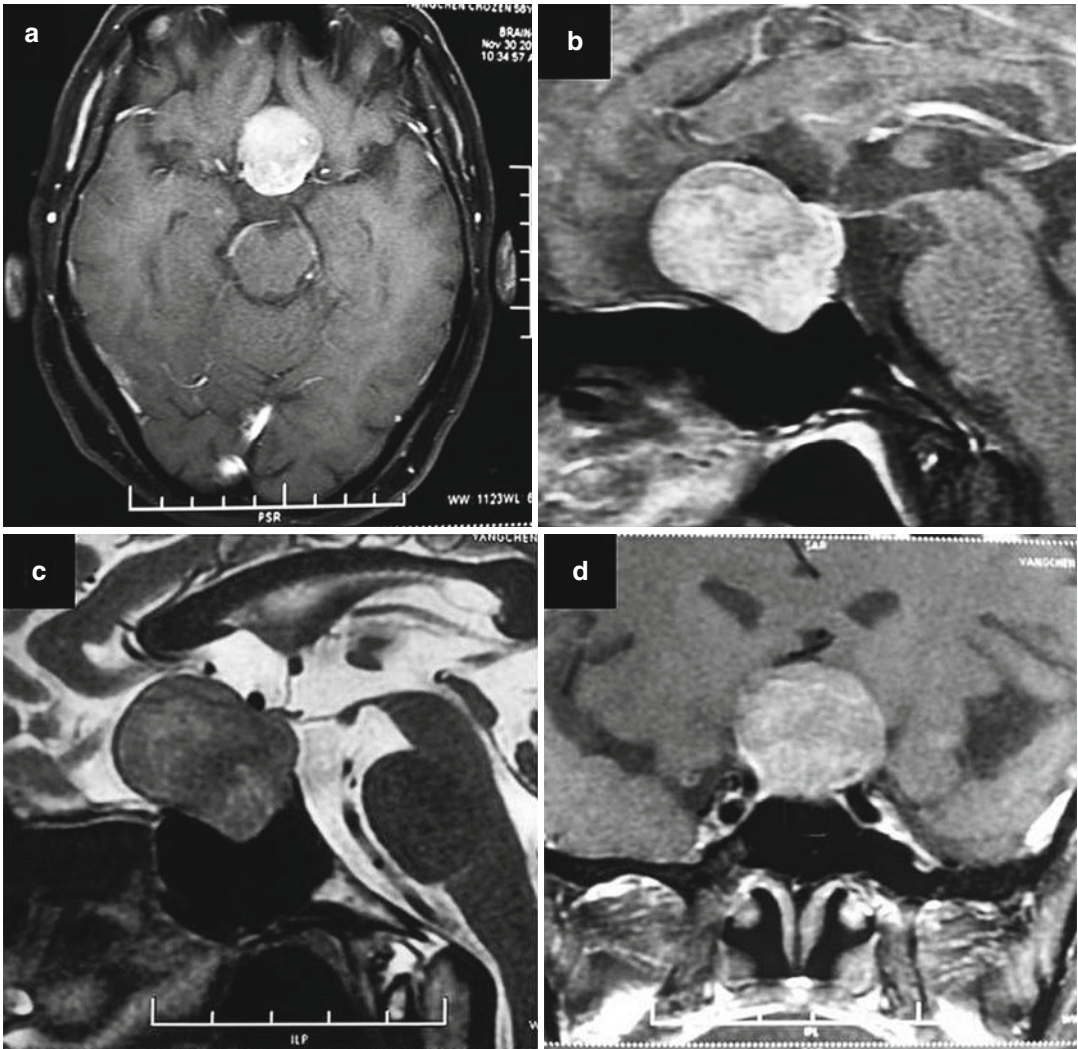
Preoperative Contrast MRI of the Brain reveal a sellar suprasellar mass lesion with significant subfrontal extension Lowerate bulging into Sphenoid Sinus: (a) Axial, (b, c) Sagittal and (d) Coronal slices
